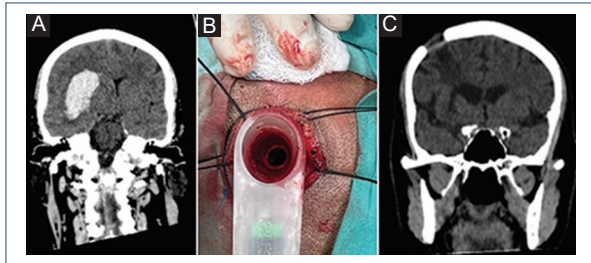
A: right intraparenchymal hematoma in the basal ganglia. B: transcortical access port. C: postoperative CT.
